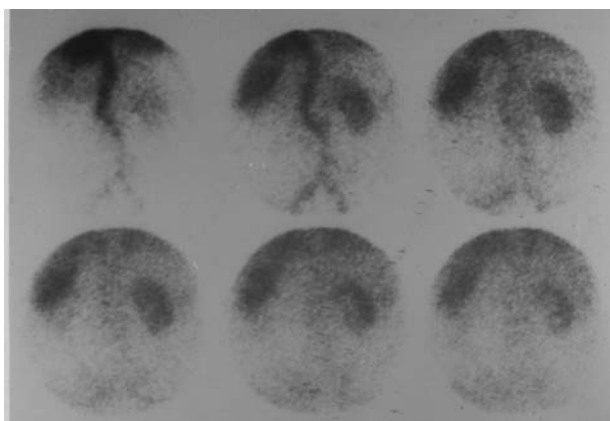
Static renal scintigraphy with ^{99m}Tc -DMSA. Accumulation ^{99m}Tc -DMSA in the aorta and blood vessels of kidneys
